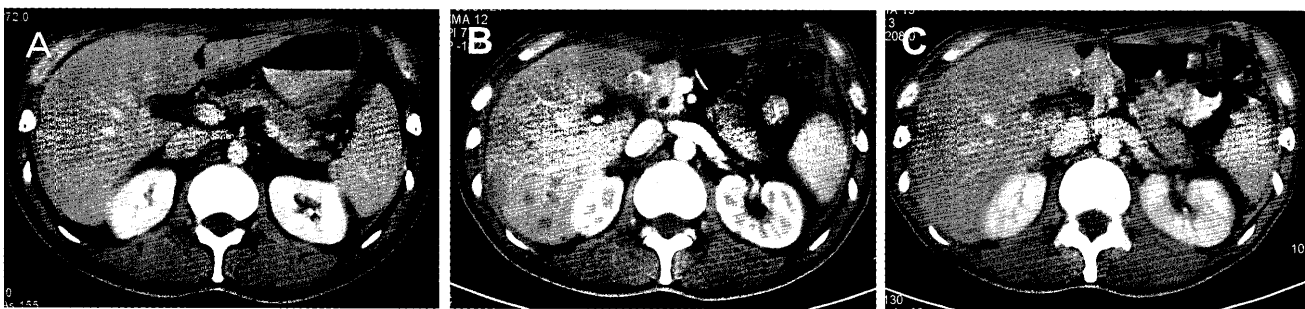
CT images of gastric cancer patient with liver metastasis. Data was from patient No.6. (A) Before surgical resection. (B) After surgical resection. Metastasized tumors are observed in the remnant liver. (C) After chemotherapy. Metastasized tumors were remarkably reduced in size.
